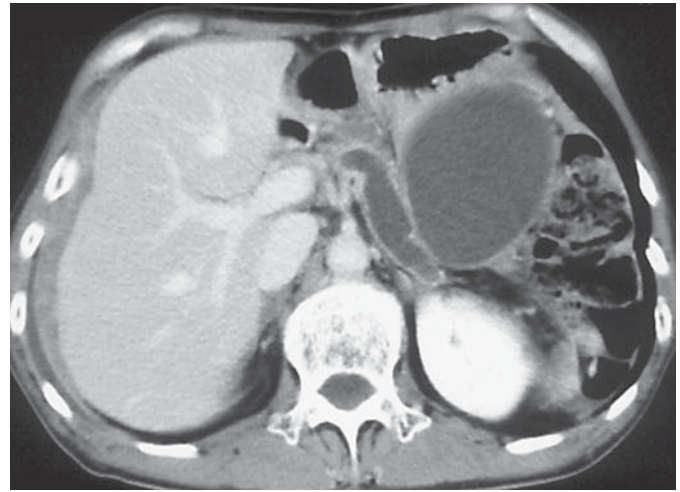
Follow-up computed tomography showing encapsulated fluid and extensive dilatation of the pancreatic duct, but no sign of progression of pseudomyxoma peritonei.
